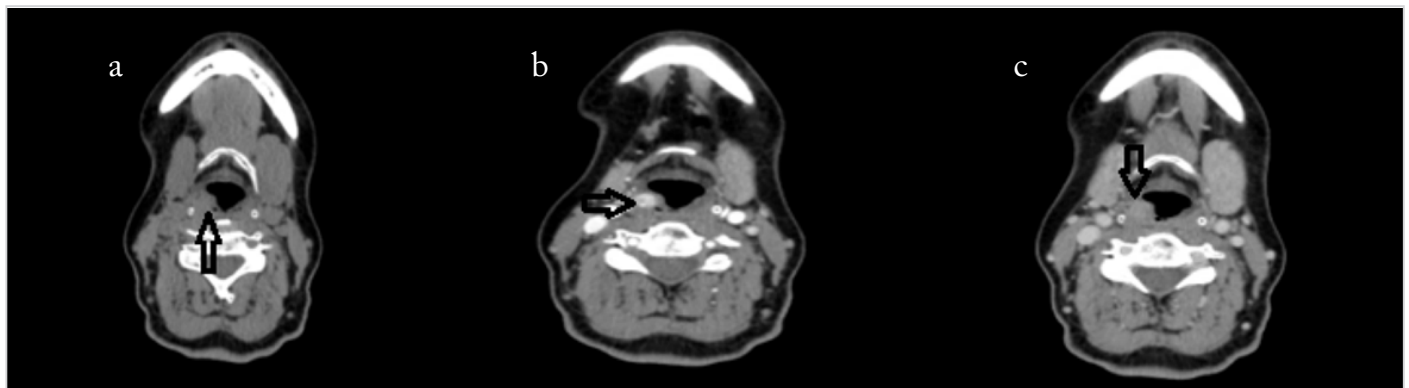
Axial sections of neck computed tomography showing a lesion consistent with parathyroid adenoma in the right pyriform sinus: pre-contrast, early post-contrast, and delayed post-contrast phases
